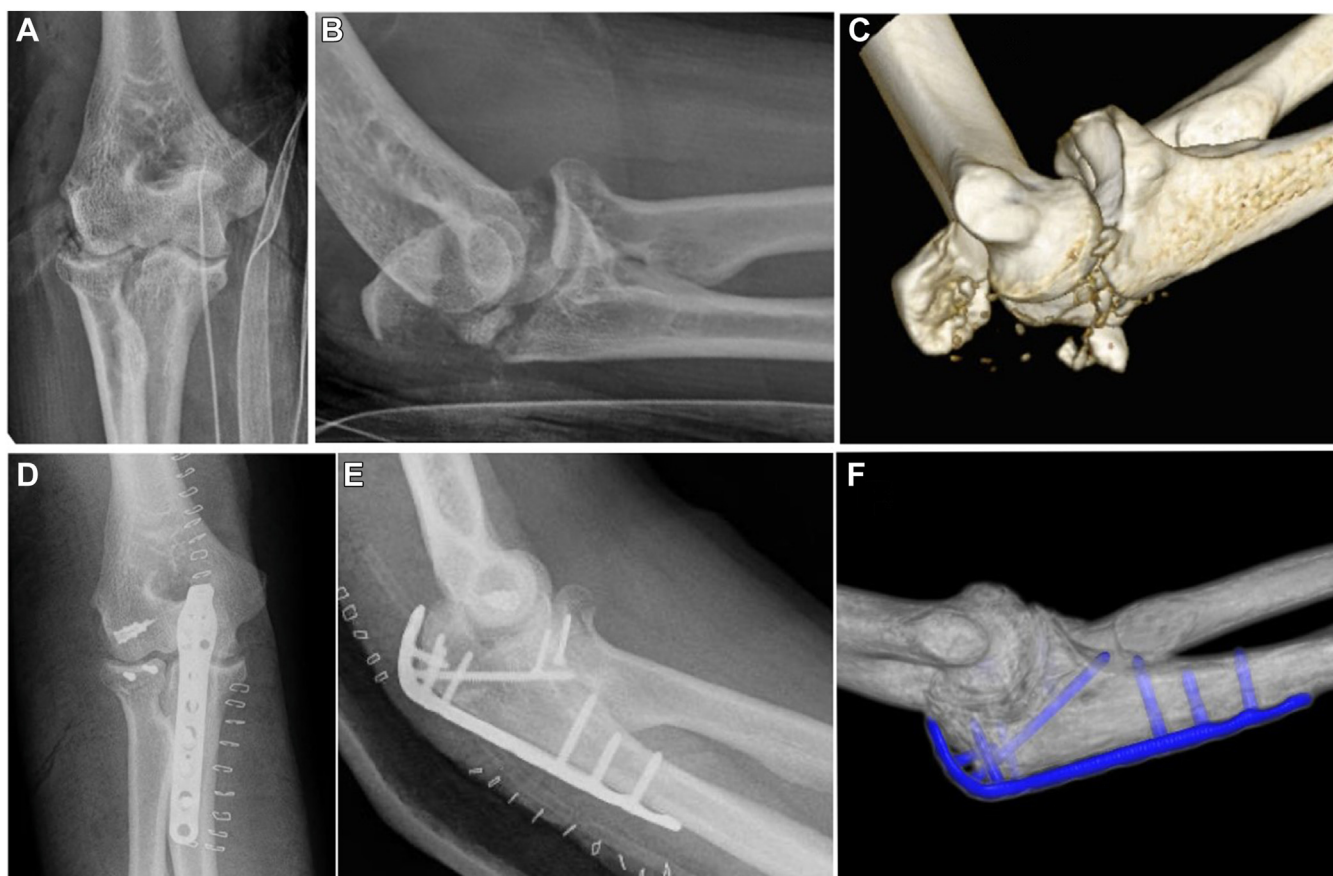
Case 17 example of pure-TOFD. (A–C) preoperative left elbow fracture-dislocations, (A) AP view X-Ray, (B) lateral view X-ray, (C) CT scan 3D reconstruction. (D and E) postoperative X-ray (D) AP view, (E) lateral view. (F) 3D reconstruction of the 6th month CT scan, complete healing. CT, computed tomography; TOFD, transolecranon fracture-dislocation.
